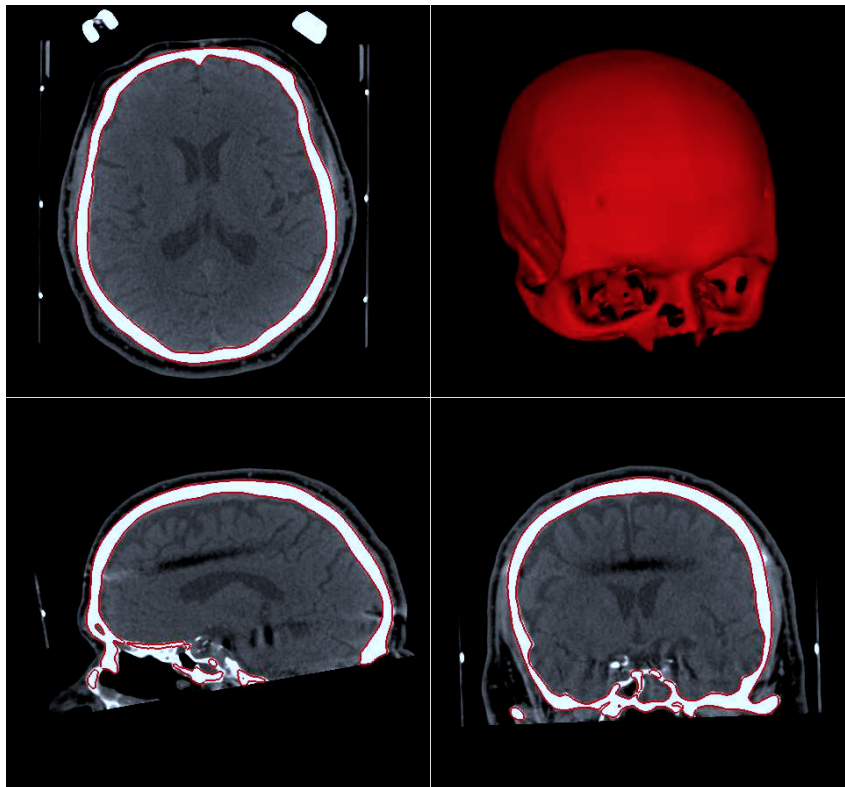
Pre-operative CT scan of a DBS patient in four views: transverse (top left), sagittal (bottom left), coronal (bottom right) and 3D view (top right). The contour in red is the segmentation of the skull (the stereotactic frame is already fixed on the skull in this image).
